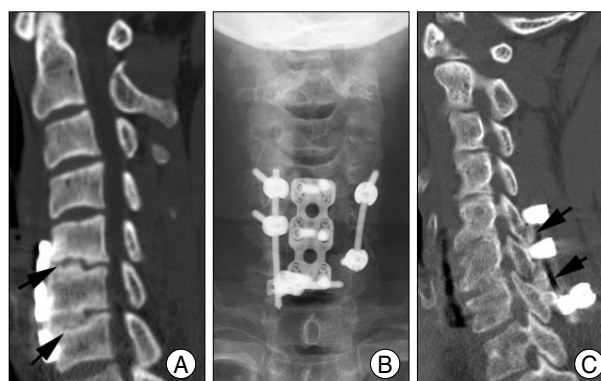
Case of C7 fixation using unilateral intralaminar screw. A : Preoperative imaging study shows pseudoarthrosis (arrows) after anterior cervical fusion. B : Postoperative X-ray shows unilateral C7 intralaminar screw on the right side and contralateral pedicle screw. C : Sagittal CT image shows the bone fusion which is successful around the lateral mass (arrows).
